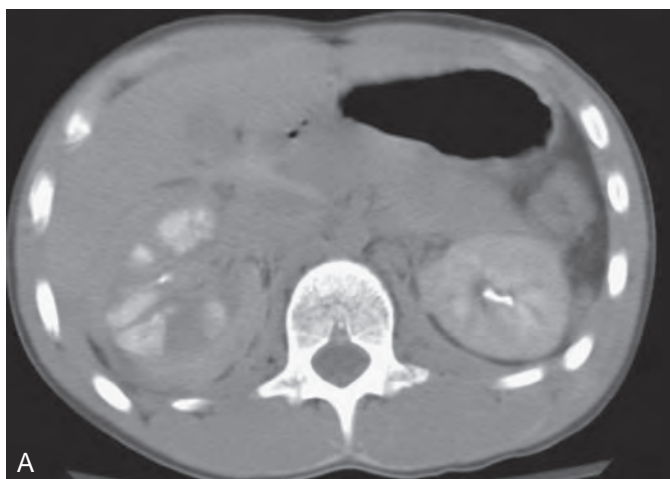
Computed tomography (CT) images of grade 3 renal trauma—patient unstable and no delayed images were performed. A and B, Acute CT images of grade 3 right renal trauma showing perinephric hematoma and multiple, less than 1-cm fractures, and association with either devitalized renal fragments, segmental renal artery occlusion, or severe renal contusion. C, Acute CT image showing no flow in distal right ureter. Patient required immediate surgical intervention as a result of acute respiratory difficulty secondary to multiple facial fractures with oral pharyngeal hematoma impairing airway. In addition, physical examination in emergency room revealed severe peritoneal irritation. Upon emergency surgery and after stabilization of patient, right retrograde pyelogram was obtained to rule out ureteral injury; no evidence of ureteral or collecting system injury was noted. Blood clot was seen to fill pelvis, and a ureteral stent was placed to aid drainage.
